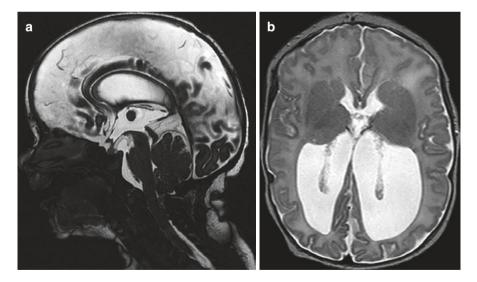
Mid-sagittal (a) MRI in a patient with MM demonstrating characteristic radiographic findings, including enlarged third ventricle, prominent interthalamic adhesion, small posterior fossa with resultant hindbrain herniation downward through the foramen magna. Axial (b) image in the same patient with occipital horn dilation out of proportion to dilation observed in the frontal horns
